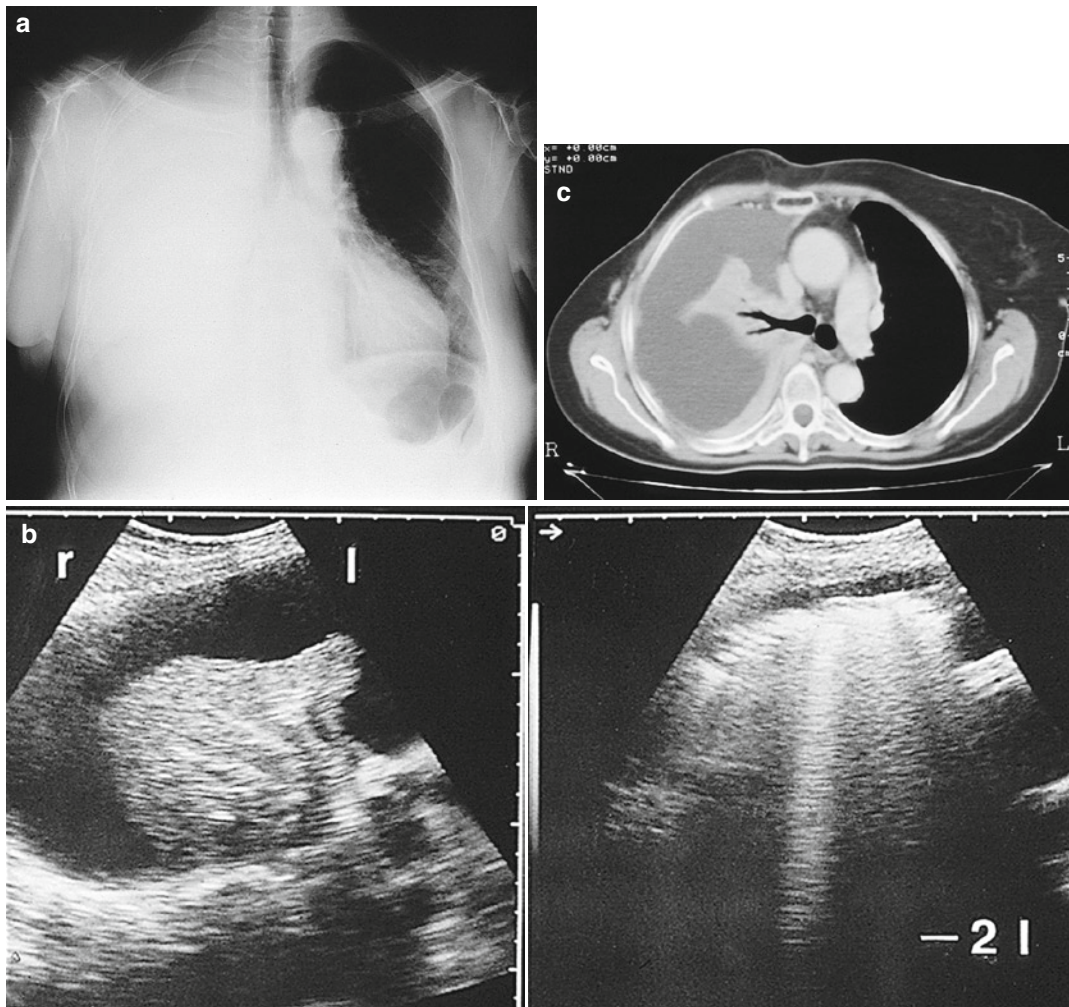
A 21-year-old woman with non-Hodgkin's lymphoma of low malignancy. (a) Chest radiograph. Complete lung opacity on the left side. (b) Ultrasonography. The lateral intercostal ultrasound beam transmission on the left side shows a markedly loculated
